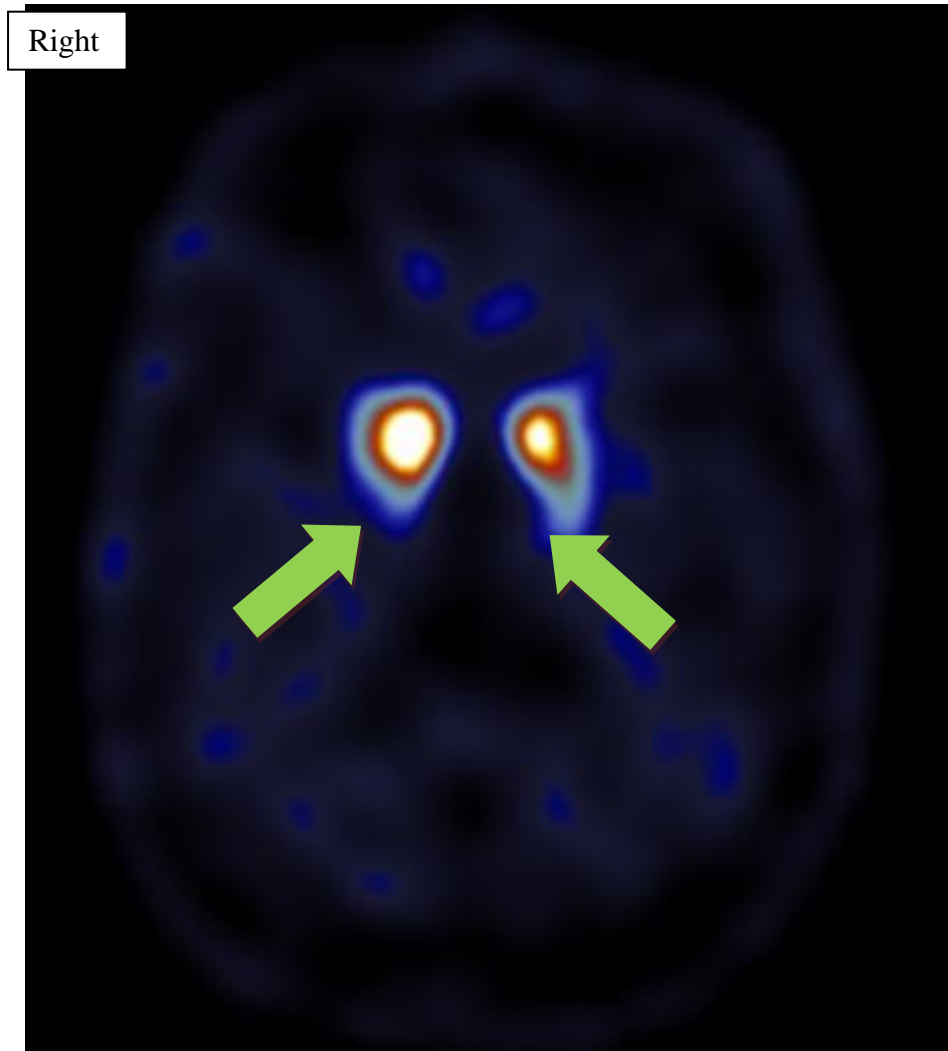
Image from abnormal FP-CIT SPECT scan demonstrating gross presynaptic dopaminergic deficit with radiotracer uptake limited to the caudate bilaterally (absent putamen uptake highlighted by green arrows).
